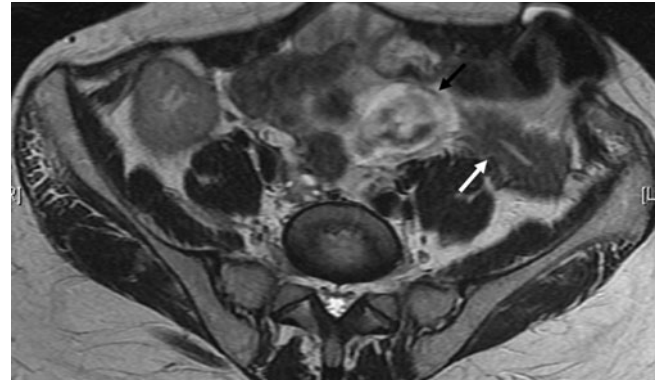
T2-weighted axial MR image showing a heterogeneous, predominantly high intensity collection sited within the left iliac fossa (*black arrow*), adjacent to the transplanted graft (*white arrow*). The transplanted kidney is sited within the right iliac fossa.
